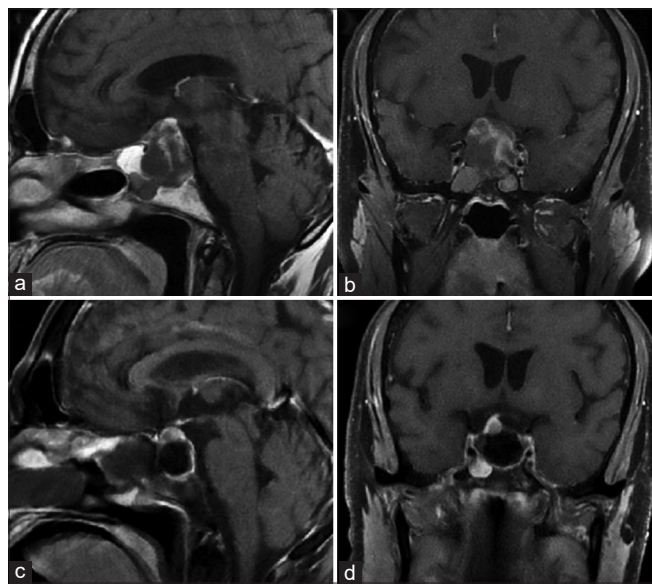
Magnetic resonance imaging (MRI) images of the current presentation. Preoperative T1-weighted images reveal a large recurrent pituitary macroadenoma with minimal patchy enhancement after gadolinium injection (a and b). Postoperative T1-weighted images with contrast revealed near total excision of the adenoma (c and d).
